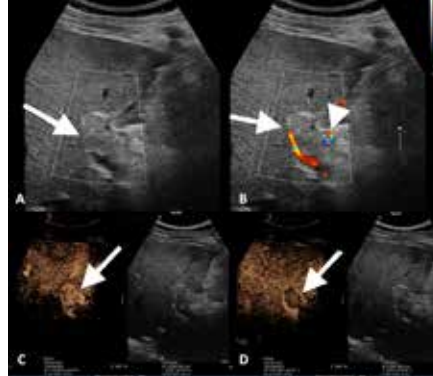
Longitudinal US scan through the portal vein showing tumour thrombus (arrow). b. Colour Doppler US scan through the thrombosed portal vein (arrow) showing vascularity within the thrombus (arrowhead). c. Contrast-enhanced US showing early (arterial phase) enhancement within the tumour thrombus (arrow). d. Delayed-phase contrast-enhanced US showing washout of contrast within the thrombus (arrow).
